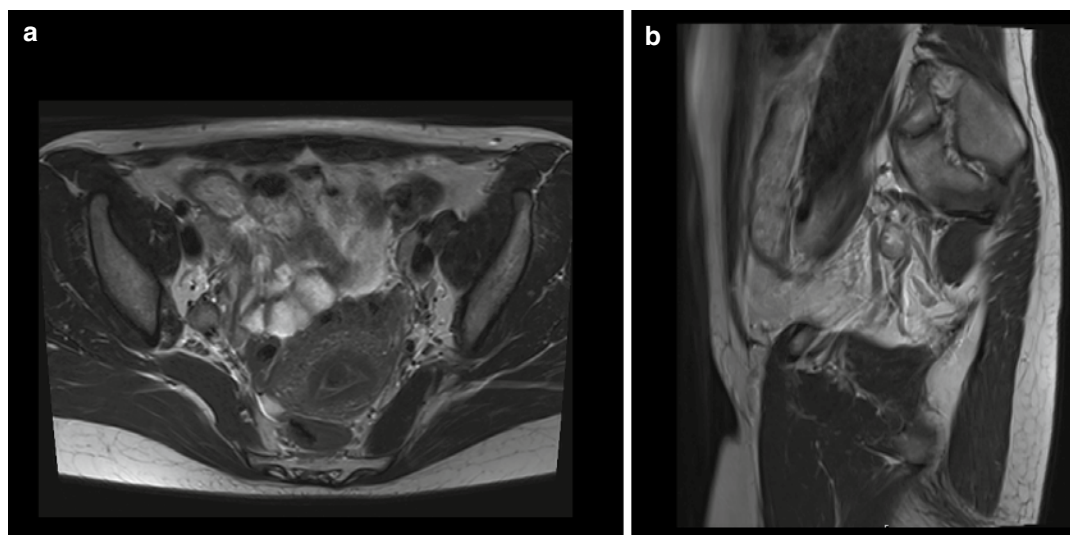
Cervix carcinoma metastasis at the right sciatic nerve. T2-weighted transverse (a) and sagittal (b) MRI scans show an enlarged lymph node suspicious as metastasis lateral to the right internal iliac vessel system riding
